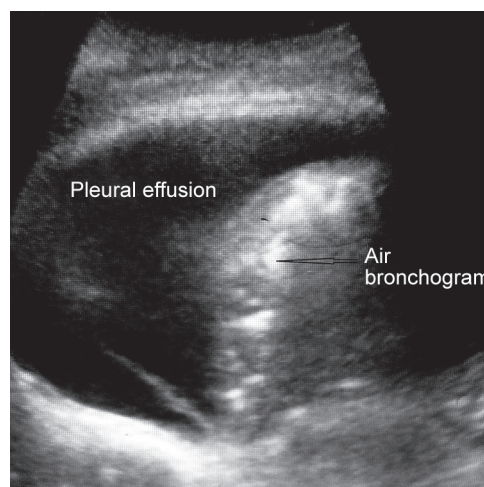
Lung ultrasound highlighting air bronchogram within lobar consolidation along with pleural effusion
